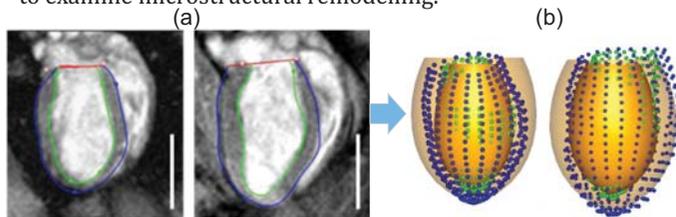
(a) Long-axis views of *in vivo* MRI of WKY and SHR hearts. (b) Subject-specific LV FE model.
